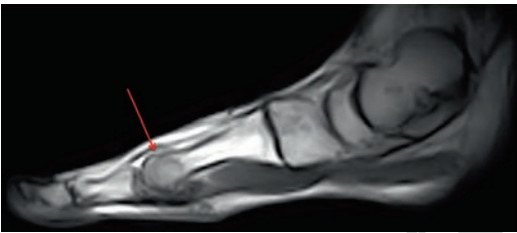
Dynamic upright MRI scan acquired in dorsiplantar flexion showing a compression oedema due to a stress fracture of the metatarsal head of the second toe
